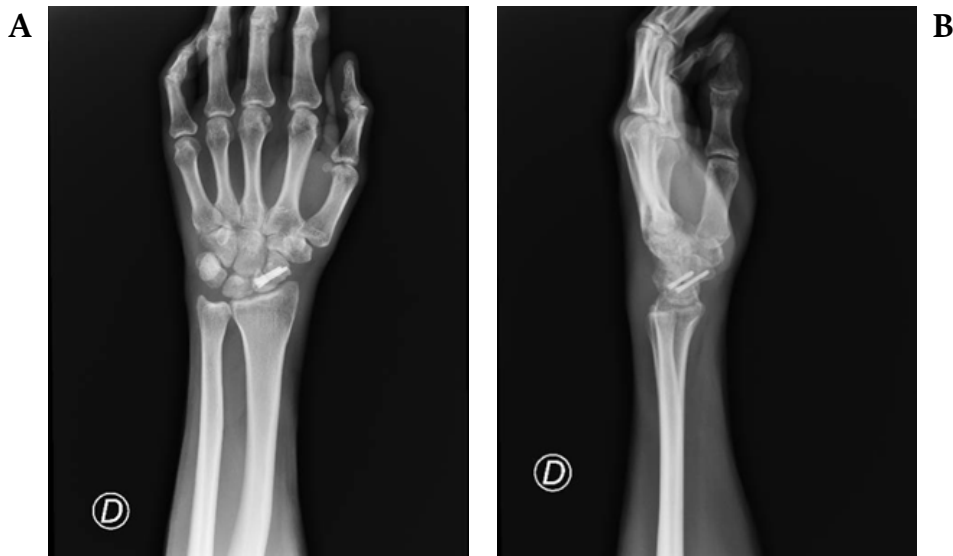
X-ray of the right wrist after removing percutaneous fixation (Kirschner wires).
